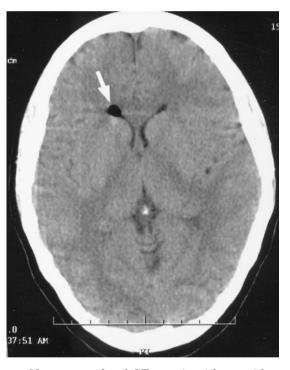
Noncontrast head CT scan is without evidence of infarction, hemorrhage, or mass effect. Note small air bubble (arrow) located in the anterior horn of the right lateral ventricle.
